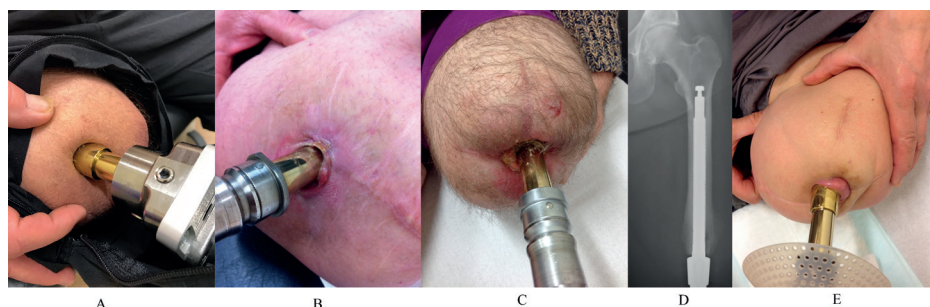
2-A Normal Stoma. 2-B Grade-1 infection. 2-C Grade-2 infection with some purulent discharge. 2-D Radiograph showing a grade-3 infection, with distal osteitis. 2-E Stoma hypergranulation.
